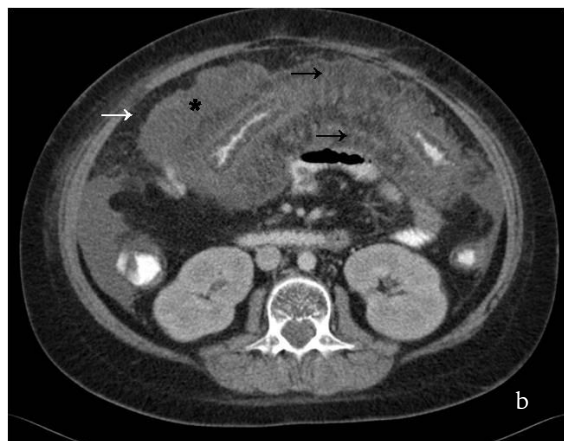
Postcontrast MRI demonstrates thickening of the transverse mesocolon and omentum (black arrows). There is a contrast-enhanced soft tissue mass appearance at the omentum (black asterisk) and fluid collections in the peritoneal cavity (white arrow).
